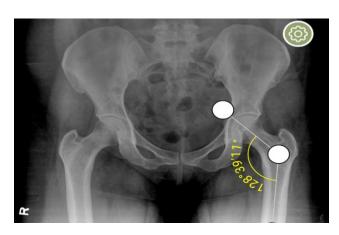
X-ray pelvis AP view.
